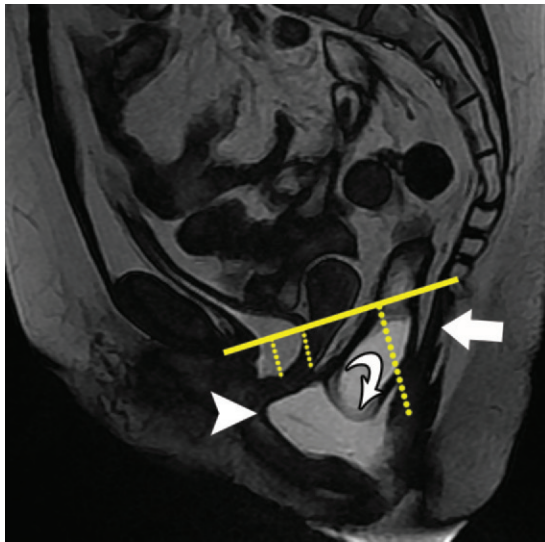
Pelvic floor relaxation or descending perineal syndrome in a 53-year-old woman with pelvic pain and chronic constipation. Midsagittal FIESTA MR image obtained at maximal effort during defecation shows descent of the anorectal junction and consequent elongation of the *M* line (long dotted line in the posterior compartment). Note also the caudal angulation of the levator plate (straight arrow), the moderate anterior rectocele (arrowhead), and the small infolding of the rectal wall indicating intrarectal intussusception (curved arrow). A mild cystocele and uterine prolapse (short dotted lines) are seen in the anterior and middle compartments. Solid line = PCL.
